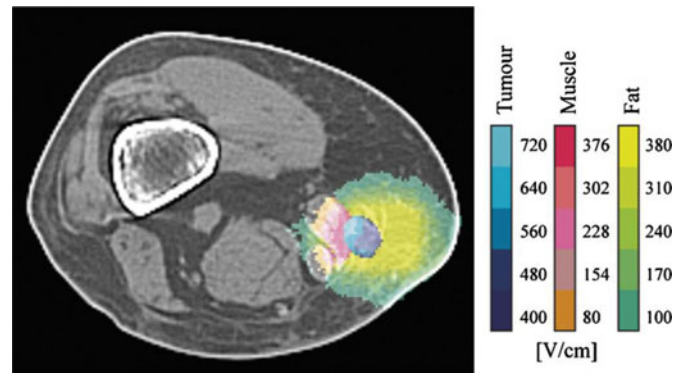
Cross section plot of the integrated tissue electroporation treatment planning methodology. The slice shows a combination of a patient melanoma CT image with the predicted electric field distribution. NTIRE ablated volume is delineated from the electric field distribution. Image adopted from [97] with permit.
